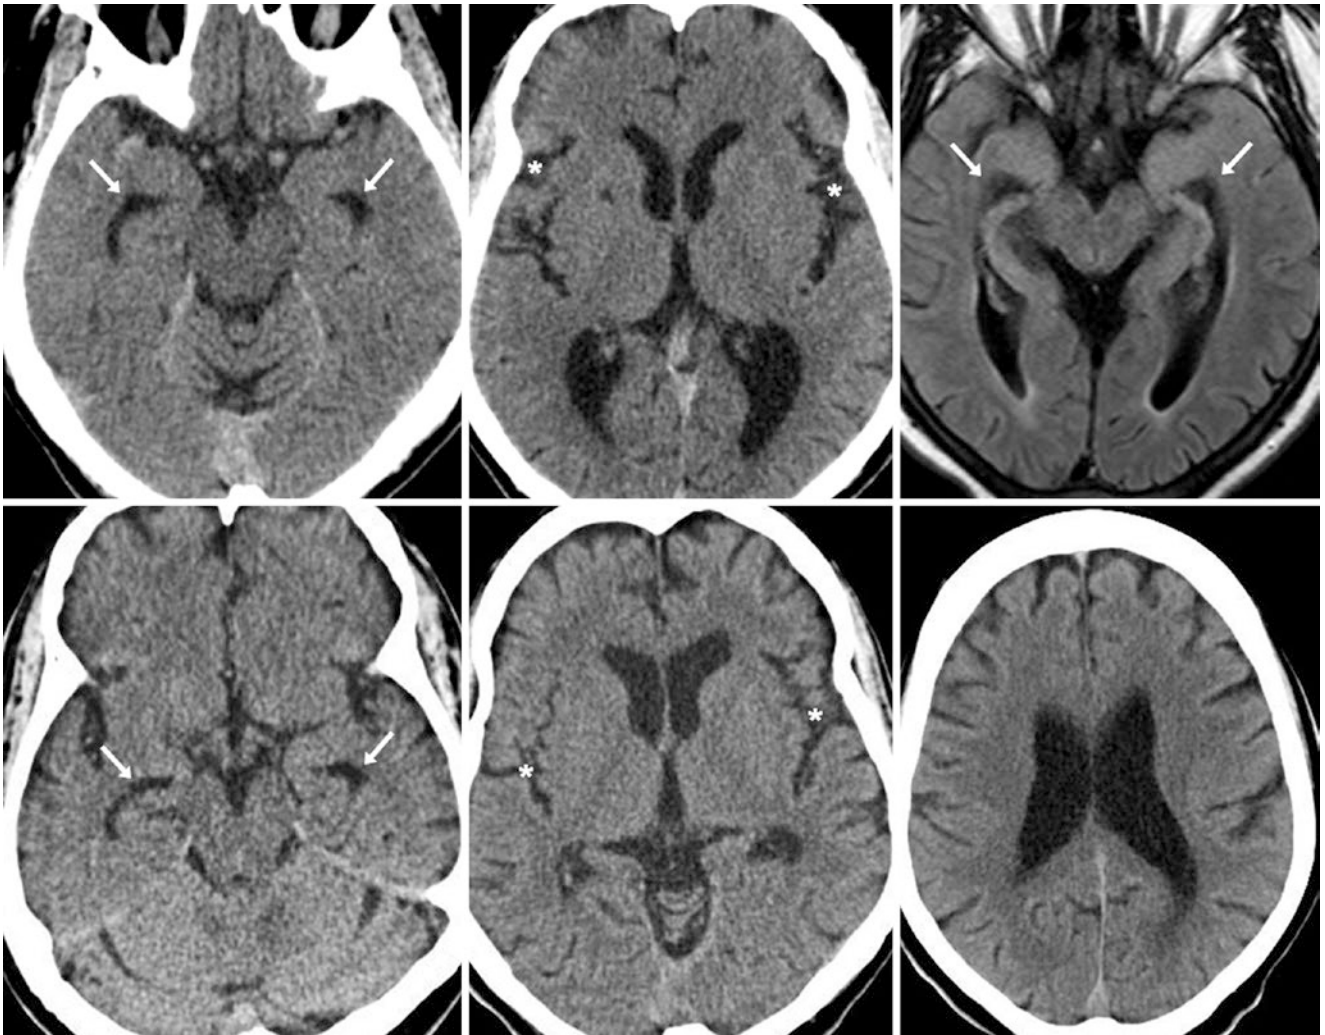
A 58 year old who showed mild prominence of the temporal horns (*arrows*) on NECT (*top left and middle*), and on 1.5T FLAIR MRI (*top right*). The temporal horns were noted to be larger than on a
